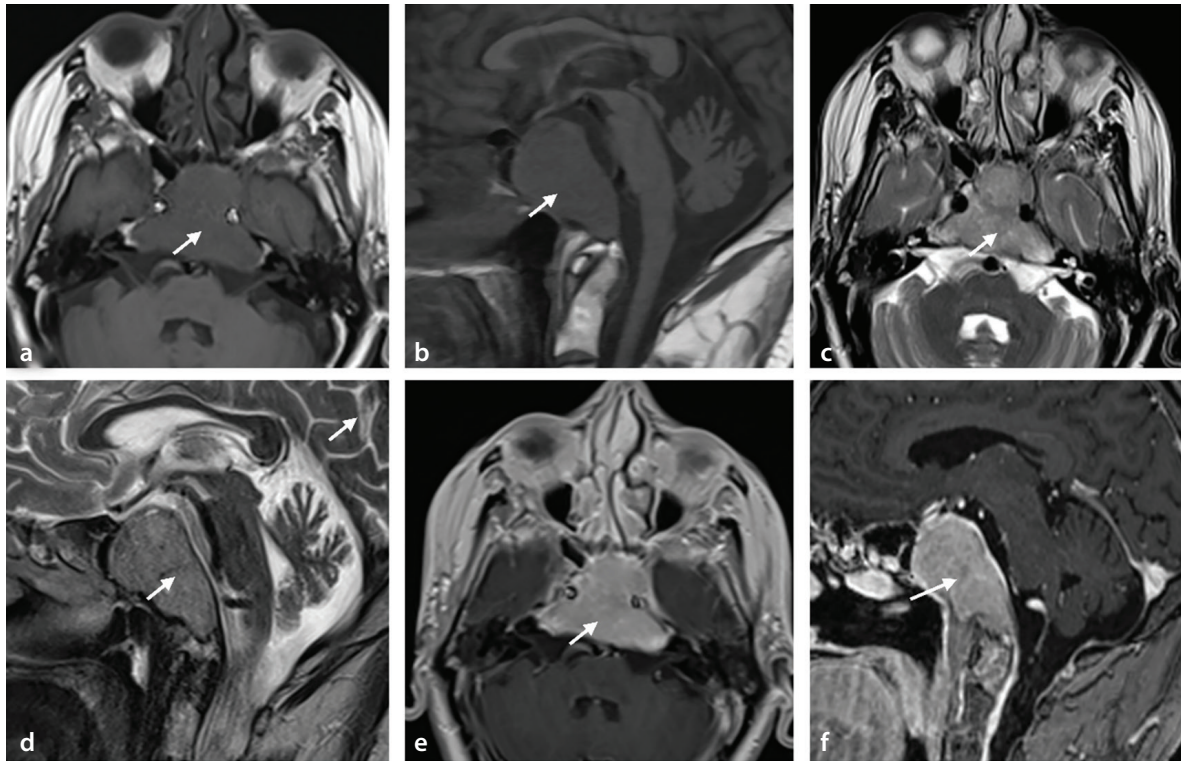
Magnetic resonance images of a 57-year-old male patient presenting with headache and restricted gaze, diagnosed with clival meningioma. The lesion (arrows) appears iso-hypointense on axial (a) and sagittal (b) T1-weighted (T1W) images and isointense on axial (c) and sagittal (d) T2-weighted images. Post-contrast T1W axial (e) and sagittal (f) images demonstrate homogeneous contrast enhancement of the clival mass, which extends laterally to the left cavernous sinus, anteriorly to the sphenoid sinus, and posteriorly to the prepontine cistern. Following the diagnosis of meningioma, the patient underwent radiotherapy.
